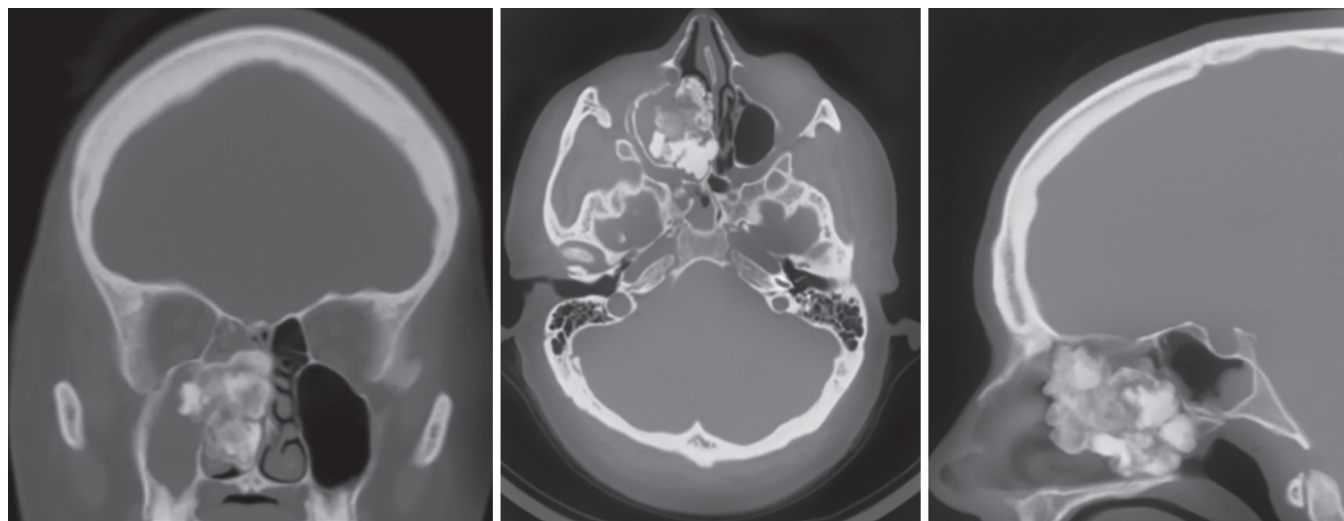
Coronal, axial, and sagittal computed tomographic imaging of an osteoma, mature type of the ethmoid sinuses. This patient was also diagnosed with Gardener's syndrome.
